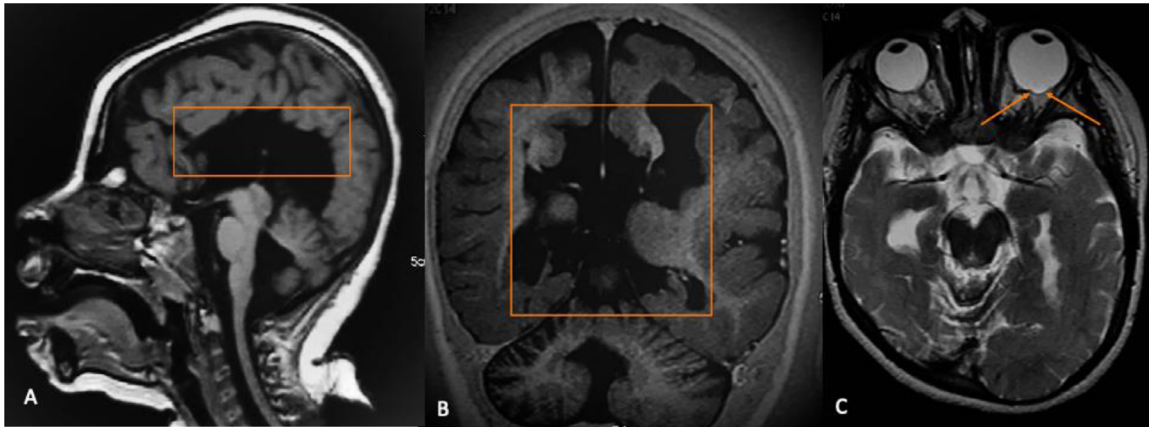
Brain MRI. T1-weighted image shows agenesis of corpus callosum (orange box in A) and a multiseptated interhemispheric cyst (orange box in B). T2-weighted image shows a left coloboma cyst located in the posterior portion of the left eyeball (orange arrows in C).
